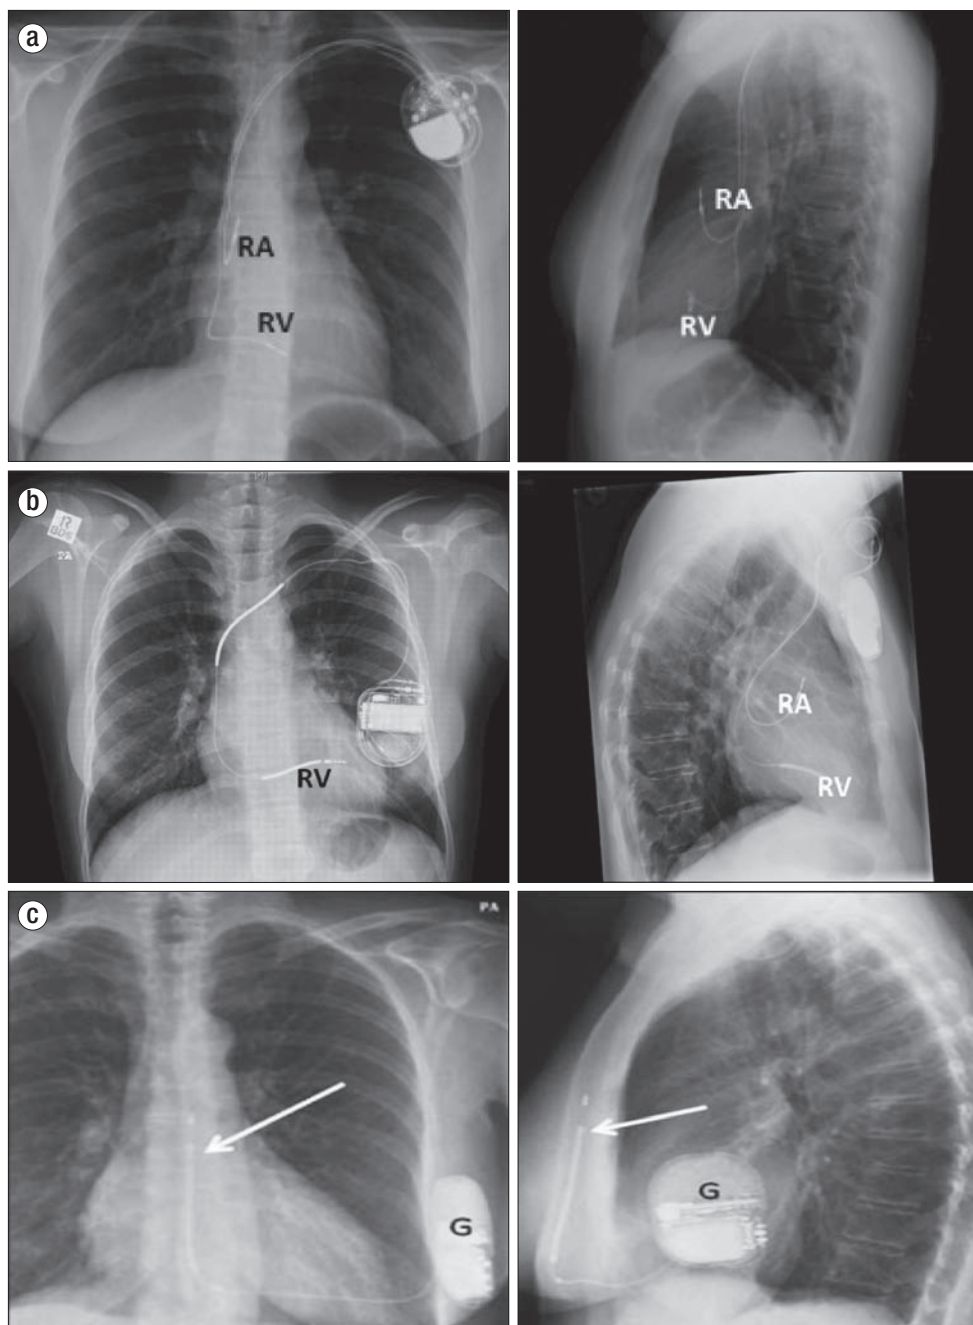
Anteroposterior and lateral views showing the appearance of different device leads on chest x-ray. (a) Pacemaker leads in the right atrium (RA) and right ventricle (RV). Some patients have a biventricular device, which would have a similar pacing lead in the coronary sinus. (b) A defibrillator lead in the right ventricle (RV). Notice the thickness of the lead due to the defibrillation coil. (c) A subcutaneous defibrillator.
